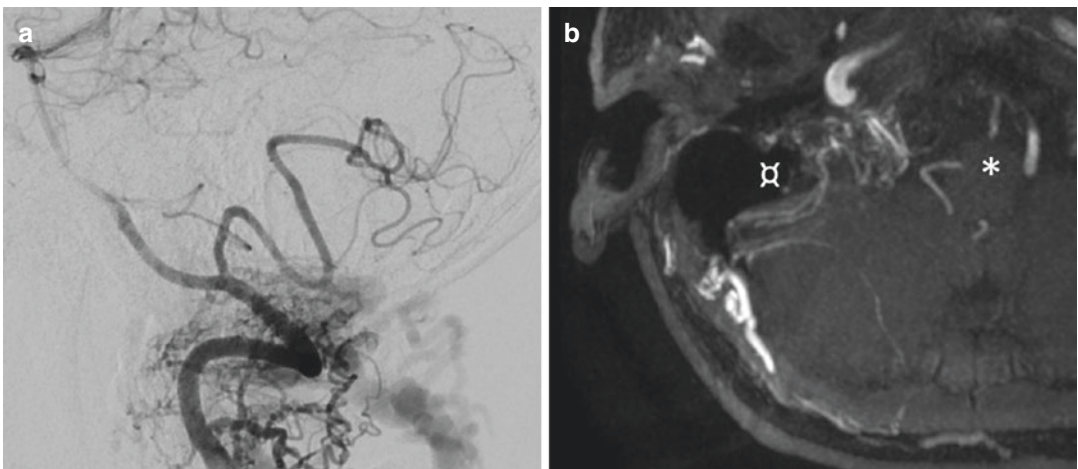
Examples of a DAVF near radiosensitive structure such as the brain stem (*) and the cochlea (⌘) in the posterior fossa (digital subtraction angiography, a, and MRI, b)
